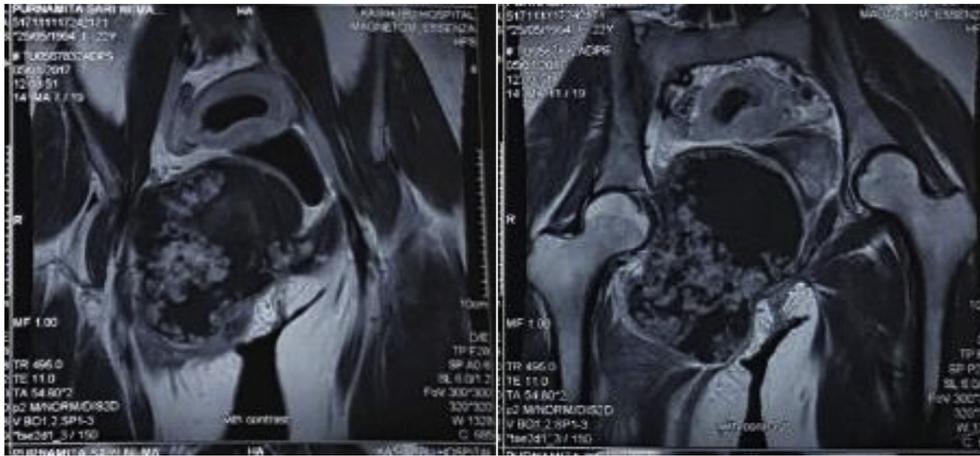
T2-weighted coronal view of pelvic MRI with contrast at 2 months pre-operative.
